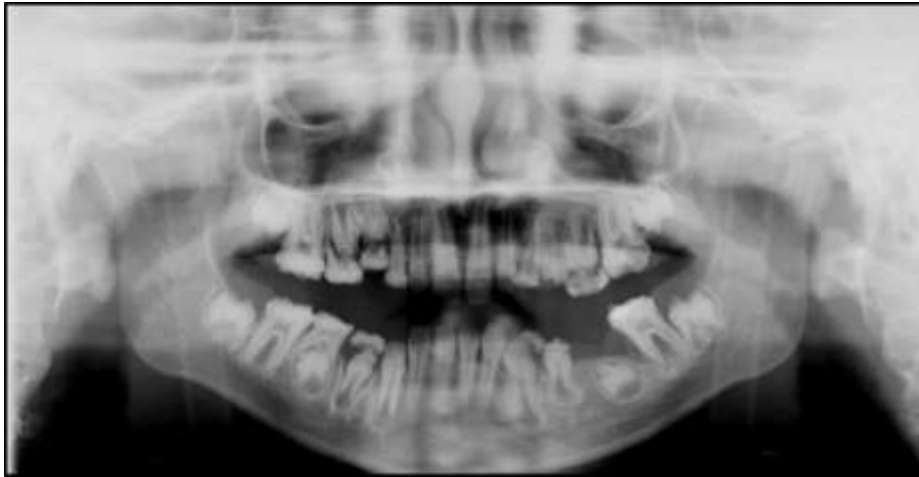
Panoramic radiograph revealed a normal sized and shaped pulp chamber and root canal spaces. The enamel was completely lost and radiopaque dentin is acknowledged
